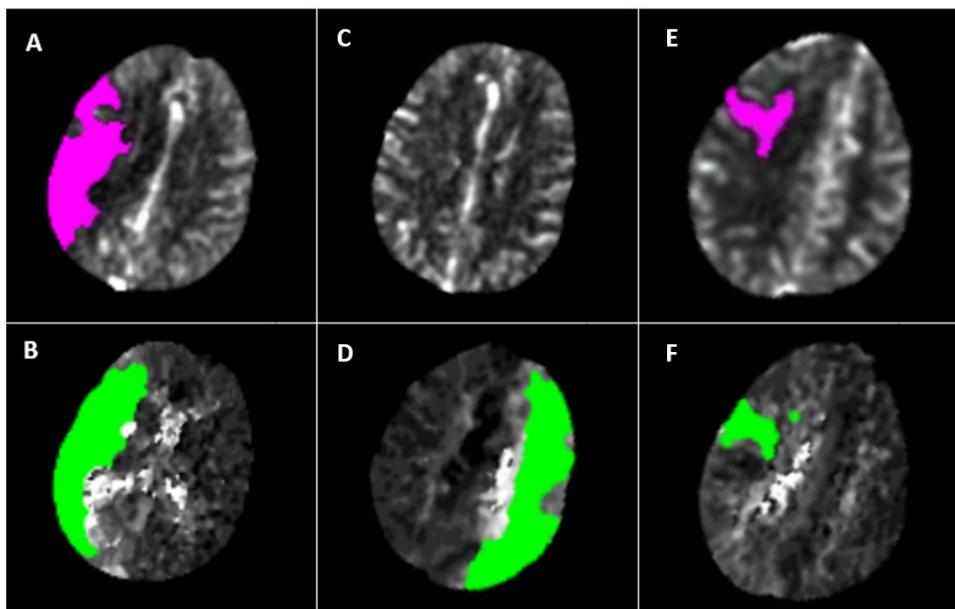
Automated CT Perfusion maps; RAPID: *A and B* - Patient 1: 72 year old male with right M1 occlusion at 1.6 hours from onset of symptoms and NIHSS 21. Core 78 mL (A), penumbra 111 mL (B), mismatch 33 mL, mismatch ratio 1.4. No thrombolysis. Thrombectomy
